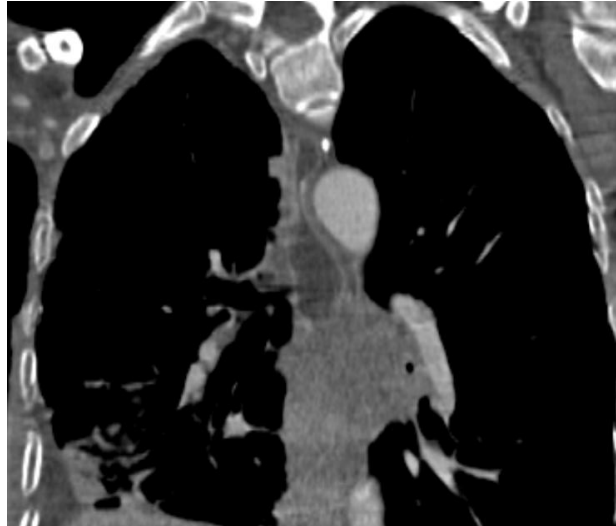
Coronal CT scan sections after injection of the contrast medium showing a gastric tumor process with peri-tumor fat infiltration.
